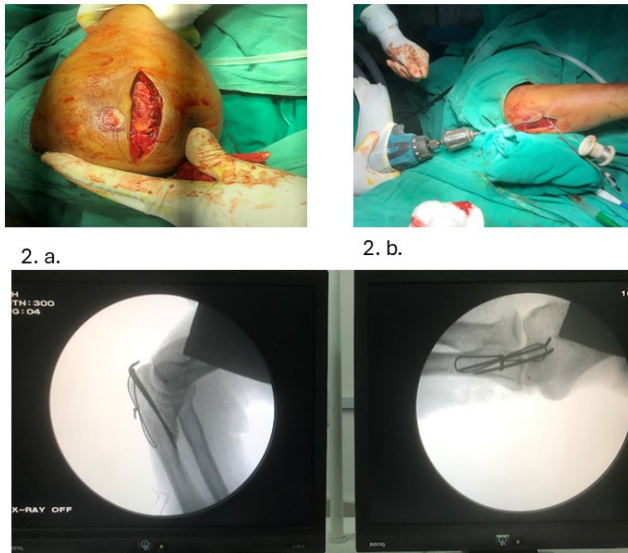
a, b: Operative images and c: Intra-operative X-ray
